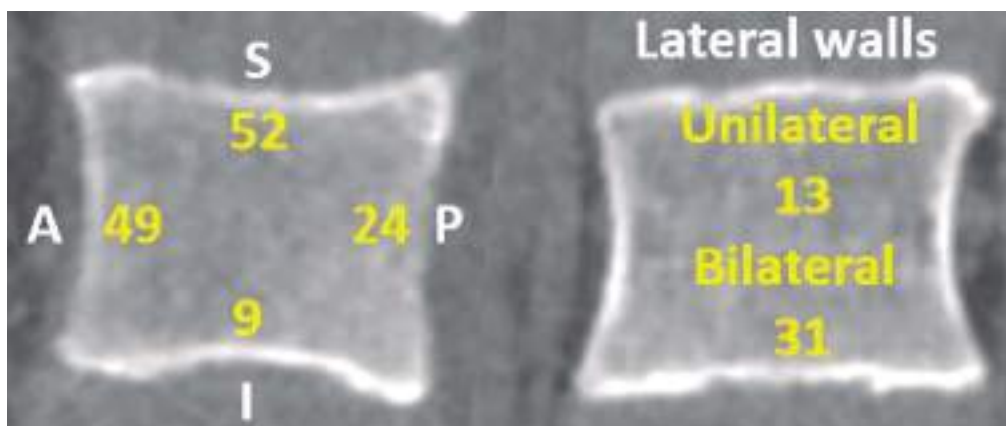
Frequency of vertebral endplates and walls involvement in our series. A. Sagittal CT image. B. Coronal CT image. A, Anterior vertebral wall. P, Posterior vertebral wall. S, Superior endplate. I, Inferior endplate.
